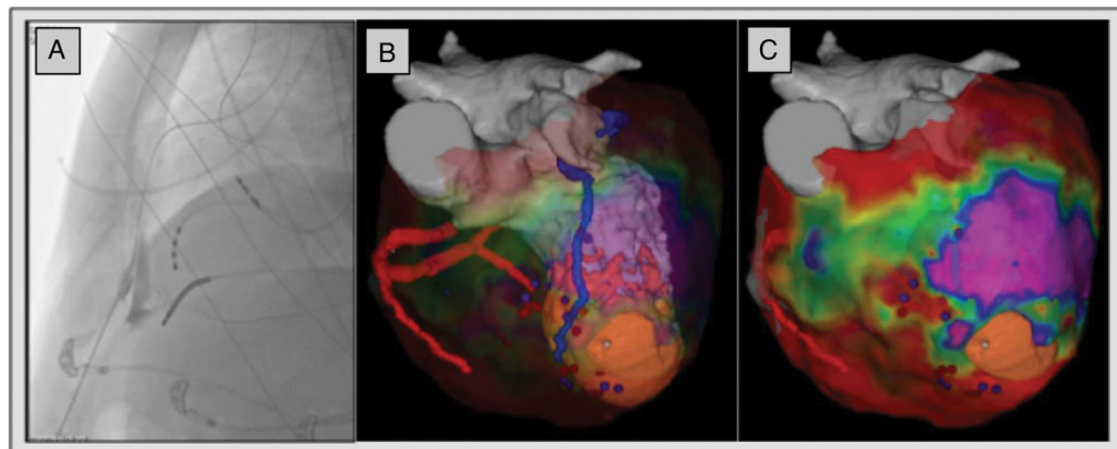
Patient 2 with ischaemic cardiomyopathy and an endocardial thrombus [anteroposterior (AP) view]. (A) Percutaneous anterior subxyphoidal epicardial puncture with Tuhoy needle using the left lateral fluoroscopic view. Contrast inside the pericardial space is seen and a guidewire freely moves within the pericardial space. A quadripolar catheter (Bard) inside the RV apex is used as anatomical landmark. Atrial and ventricular leads of intracardiac defibrillator are visible. (B) Merged image of transparent epicardial voltage map and three-dimensional mesh (derived from DE-MRI) made using Music[®] software with coronary artery system in red, coronary venous system in blue, and scar in orange. Local abnormal ventricular activity tagged in purple and ablation points are tagged in red. (C) Epicardial bipolar voltage map with merged image and EAM image, using the CARTO[®]3 system (Biosense Webster). Purple is normal voltage >1.5 mV, green is borderzone >0.5 to <1.5 mV, and red is dense scar or epicardial fat <0.5 mV. A hole is visible at the pericardial adhesions above the apical scar.
